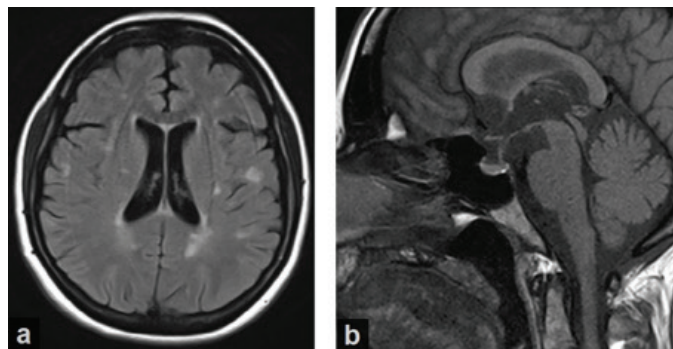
Brain magnetic resonance imaging of the patient: a) Demyelinating plaques on axial image; b) Sagittal section image of the pituitary gland and hypothalamic region
